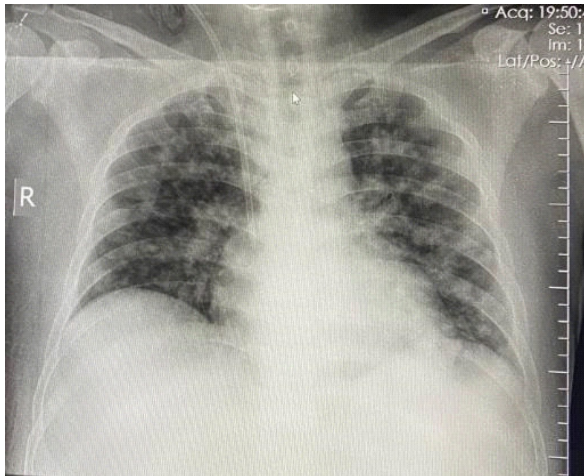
Radiograph of patient in day 5
